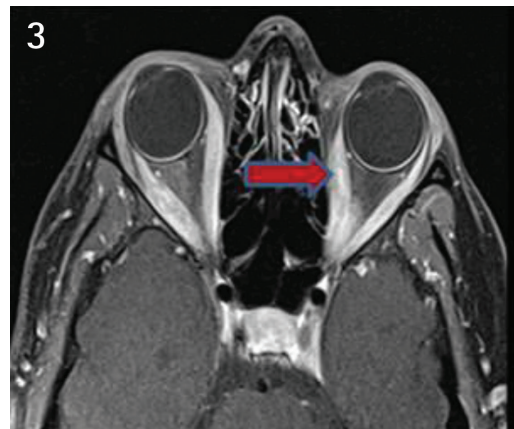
Magnetic resonance imaging of the orbit showing inflammation in the bilateral extraocular muscles which was more pronounced in the left medial rectus
